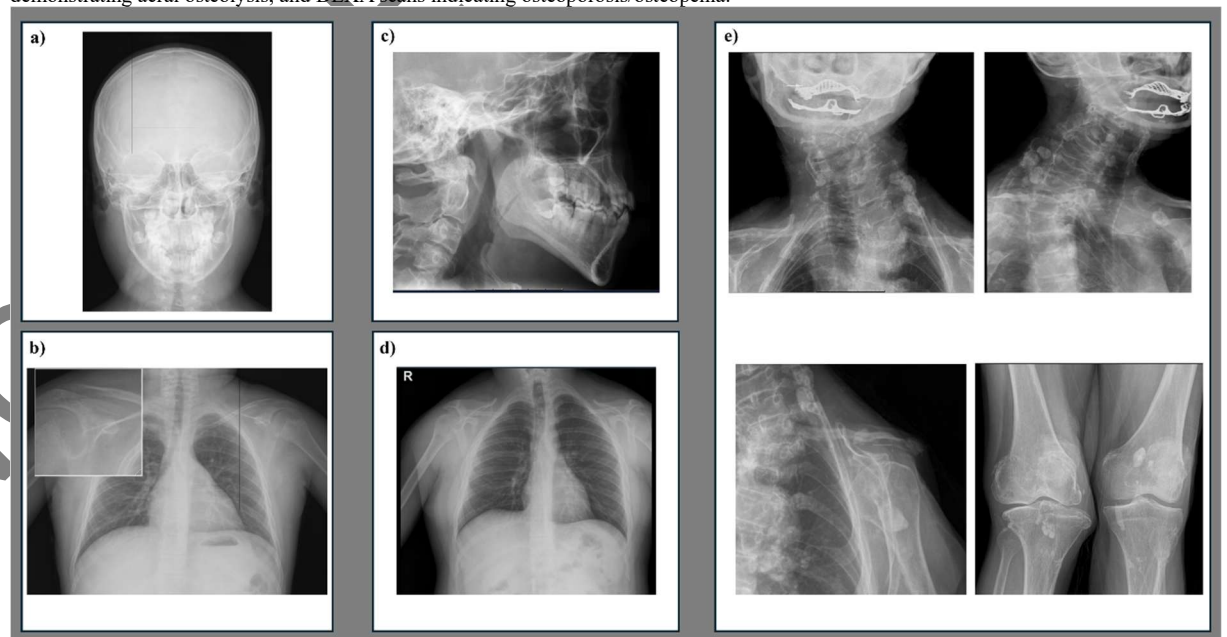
a) Patient 1; skull X-ray demonstrating mandibular hypoplasia. b) Patient 1; increased radiolucency of the distal clavicle. c) Patient 3; lateral skull X-ray demonstrating the absence of mandibular hypoplasia. d) Patient 3; normal clavicle. e) Patient 4; mandibular hypoplasia, soft tissue calcifications, marked irregularity and increased radiolucency of the distal clavicle, advanced degeneration of joint-facing bone surfaces, osteoporosis in bone structures, and vertebral height loss.
